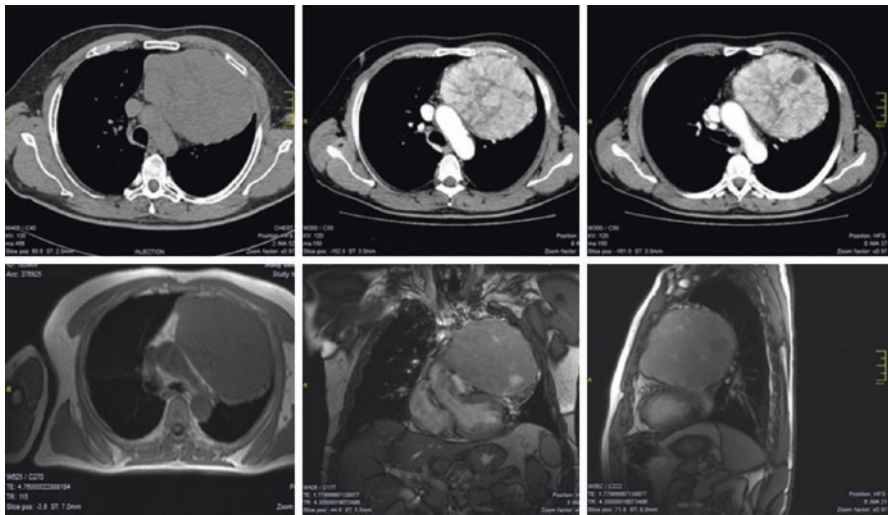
Chest CT scan without and with mdc/chest MRI with T1w and T2w sequences: thymoma. Voluminous and inhomogeneous mass, occupying space: hypodense in sequences without contrast and it becomes hyperdense after contrast medium. At the MRI, it appears hypointense in both T1w and T2w sequences with some hyperintense spots in the T2w sequences to refer to probable colliquation phenomena
